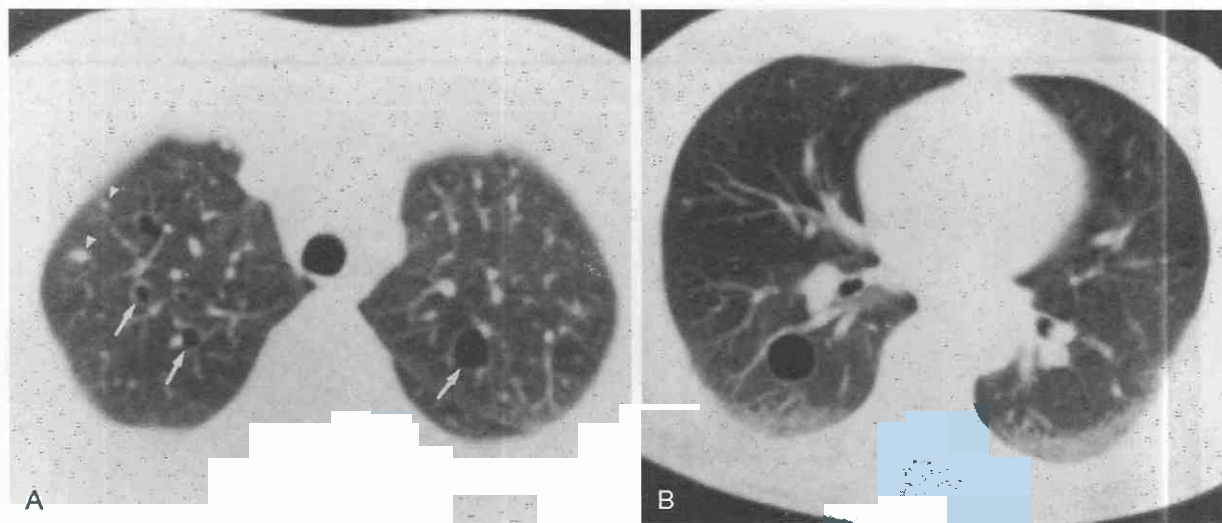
A and B, Early Langerhans' cell histiocytosis involving the lung. CT shows multiple, thin-walled regular cysts (arrows) and tiny nodules (arrowheads). (From Kuhlman JE, Reyes BL, Hruban RH, et al: Abnormal air-filled spaces in the lung. Radiographics 13:47-75, 1993.)
